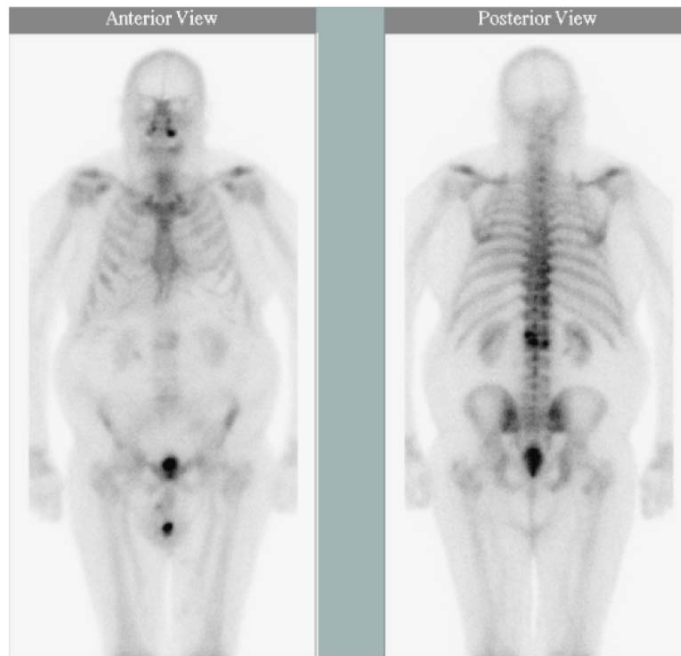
Bone scintigraphy showing a pathological osteoblastic reaction in L1 and L2.
